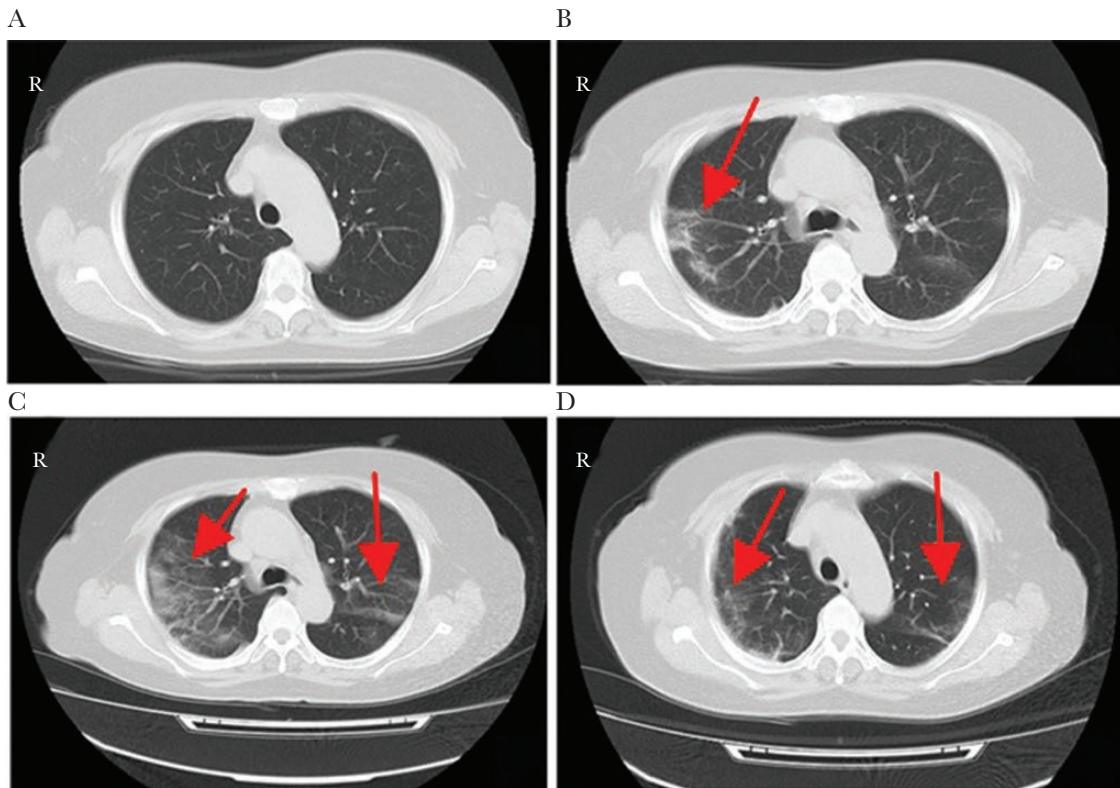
Representative thoracic computed tomographic scans of a patient with severe illness, showing normal findings on admission day 1 (A), diffuse patchy shadowing (arrow) on day 5 (B), more diffuse patchy shadowing (arrows) on day 8 (C), and recovery stage on day 15 (D). R indicated the right lung.
